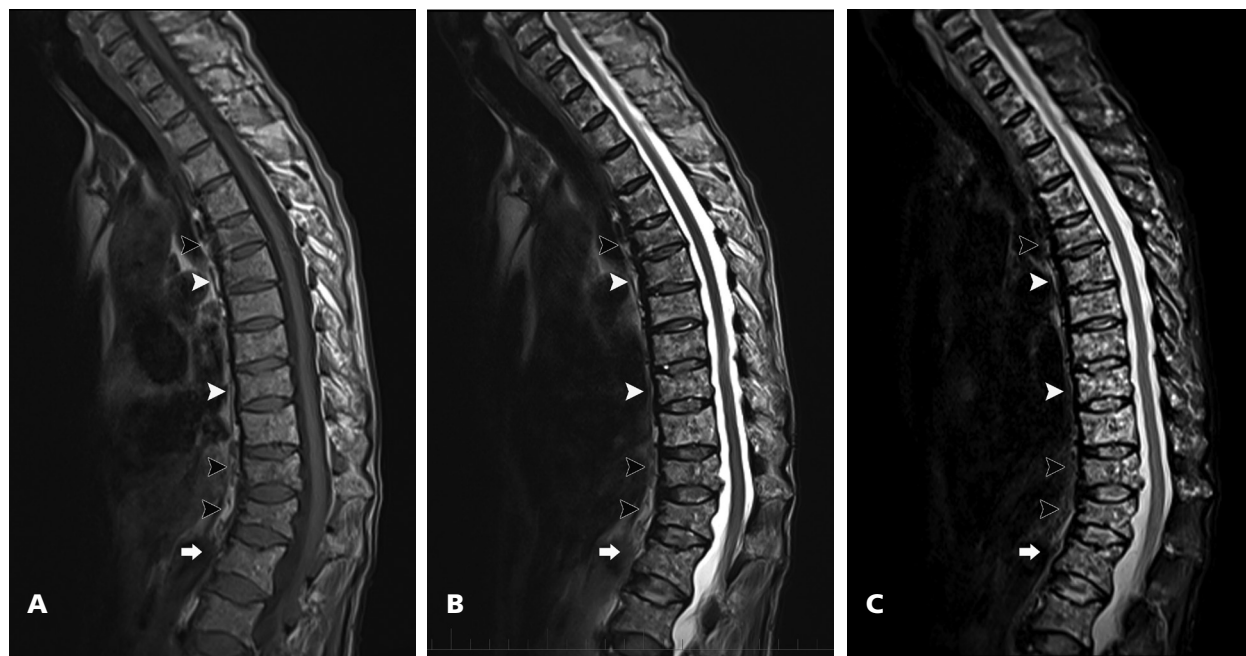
Imaging of the patient's thoracic spine upon presentation, including (A) thoracic MRI T1, (B) thoracic MRI T2, and (C) thoracic MRI STIR sequences. L1 (light arrow) is visible, demonstrating a stable wedge fracture from previous lumbar MRI. The T6 and T9 vertebrae (light arrowheads) also appear to have stable compressions when compared to previous CT imaging. However, there are distinctly new vertebral body compression fractures at T5, T11, and T12 (dark arrowheads). Again, diffuse abnormal bone marrow signal changes and enhancement are present, which is consistent with MM, but there is no noticeable development of BME indicating acute fracture events. All fractures were read as chronic by the radiologist.
